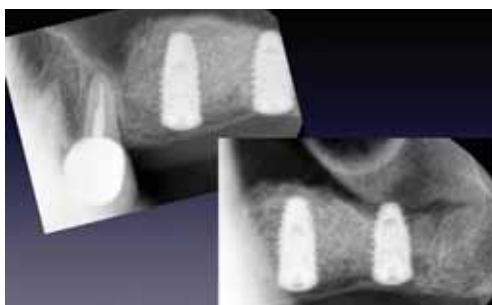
Periapical radiographs after implant placement.
